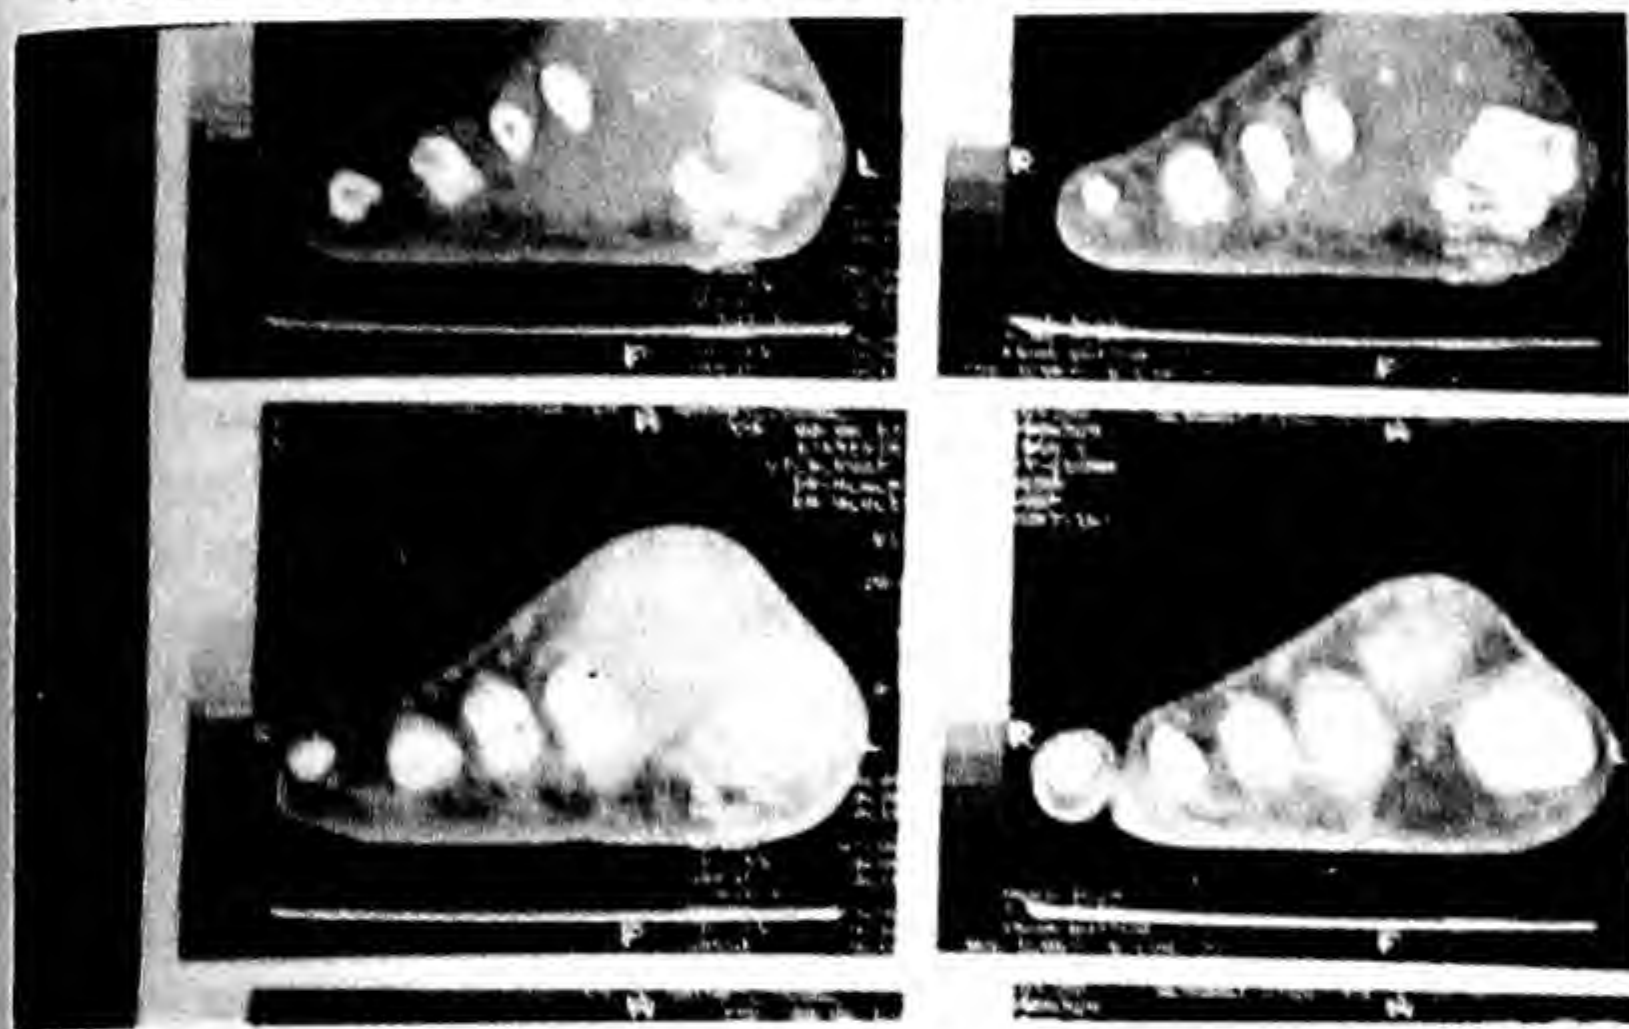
CT Scan showing soft tissues swelling between the metatarsals extending from planter to dorsal aspect with ill-defined margins.
